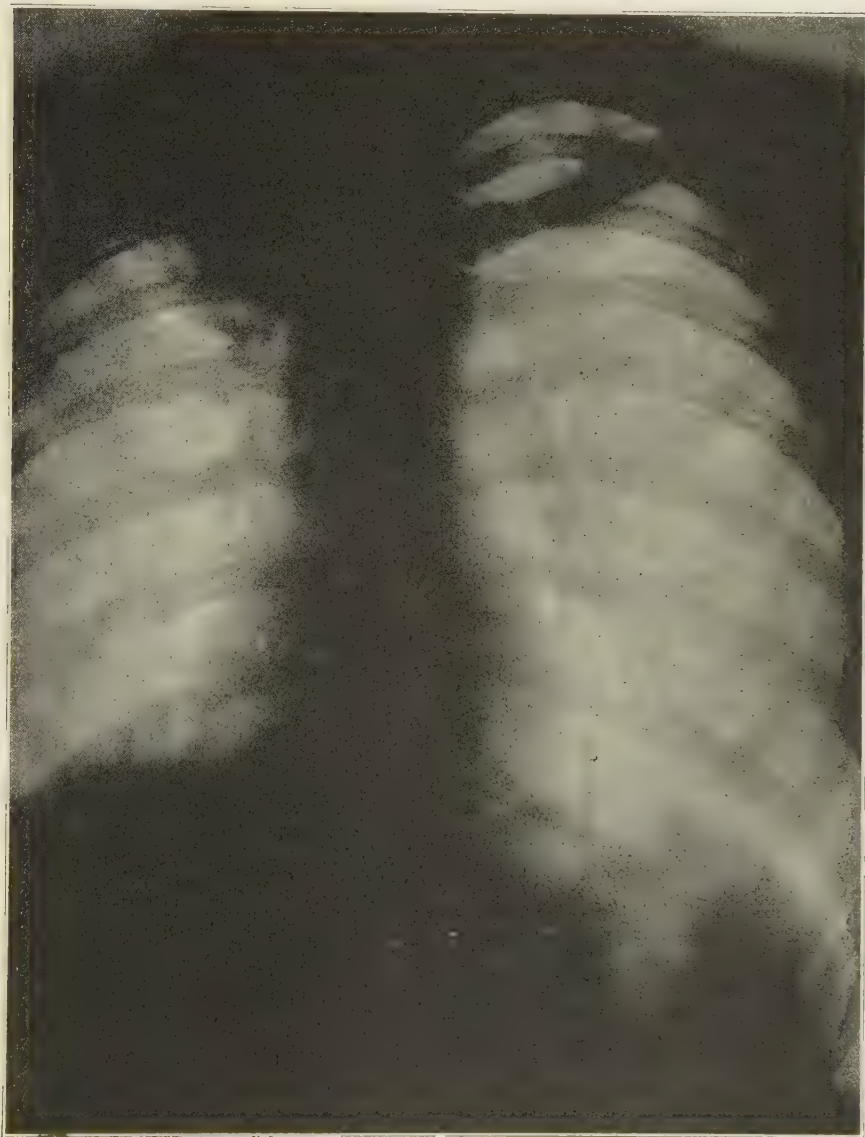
Artificial pneumothorax. Radiograph of the chest before collapse of right lung. Note advanced lesion in right apex only.
